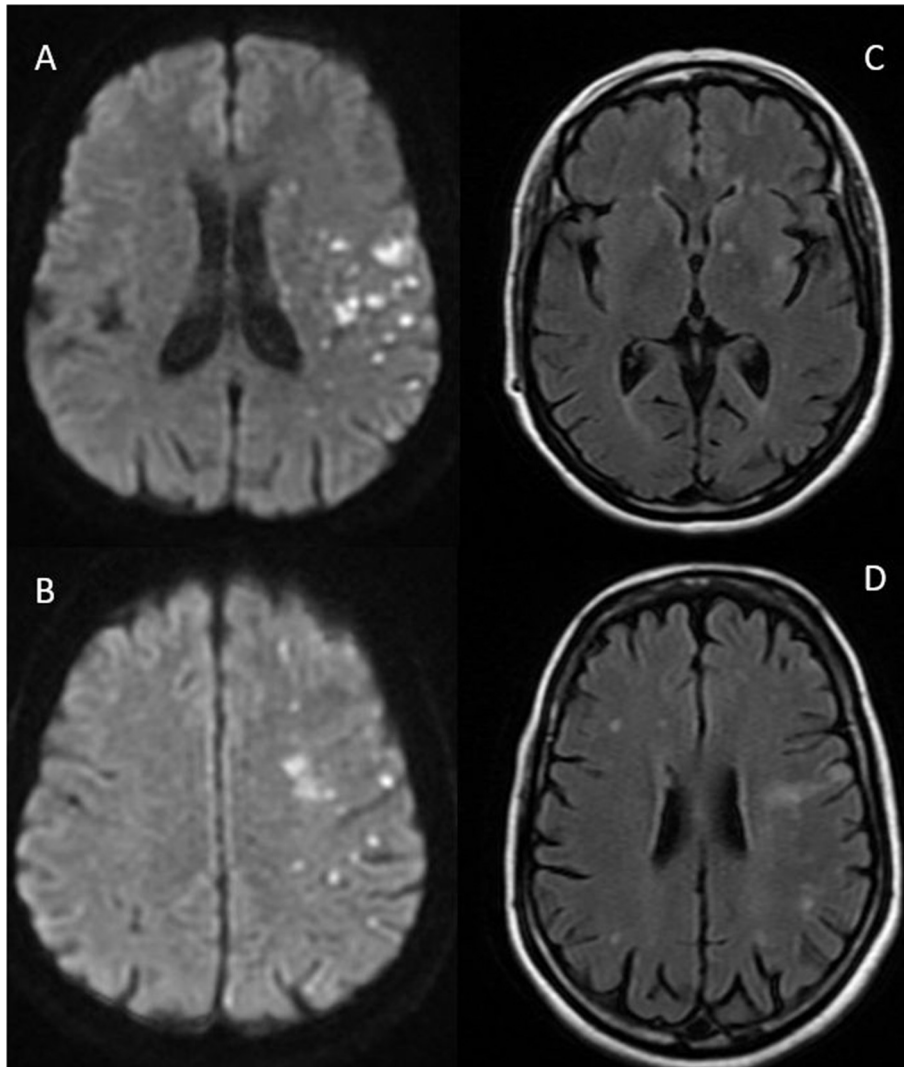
MRI of the brain (diffusion-weighted MRI) showing multiple small acute infarcts in the region of the left middle and anterior arteries compatible with an infarct of embolic origin (A, B). Axial fluid-attenuated inversion recovery (FLAIR) MRI image in chronic phase demonstrating residual areas of cerebral ischemia (B, C).
